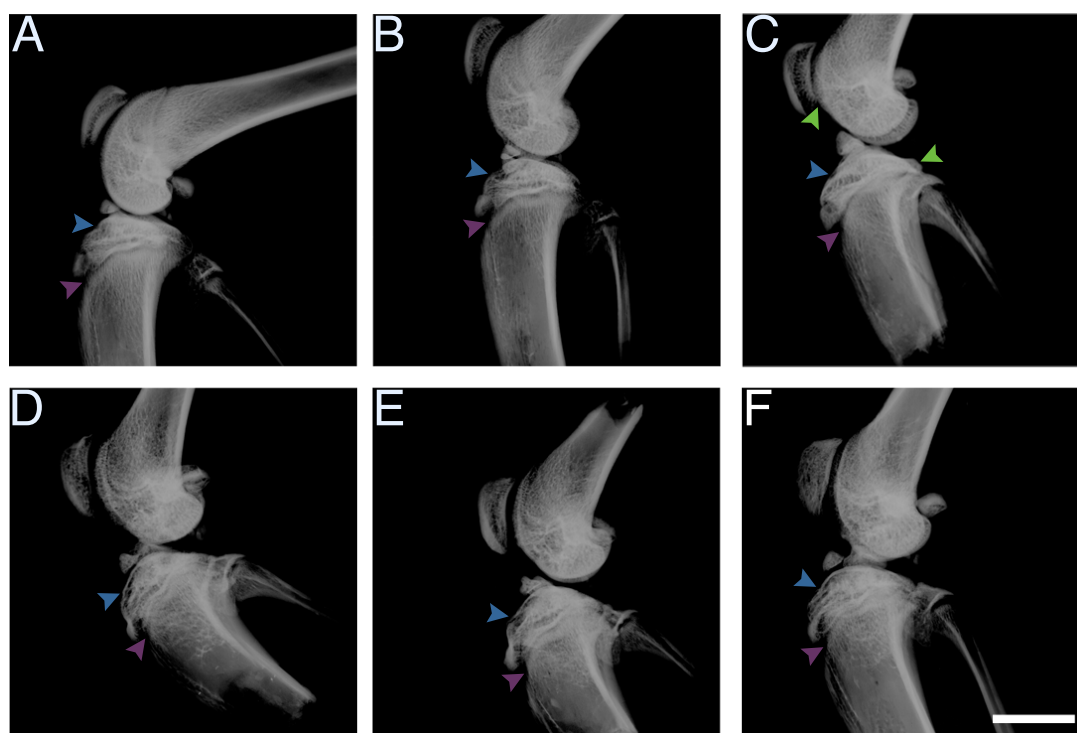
Dual antagonist treatment improves radiological indices of OA: X-ray results. A) no surgery and saline treatment; B) sham surgery and saline treatment; C) ACLT and saline treatment; D) ACLT and BQ-123 treatment; E) ACLT and R-954 treatment; F) ACLT and BQ-123+R-954 dual treatment. Blue arrows indicate tibial plateau, purple arrows indicate subchondral bone, and green arrows indicate osteophytes. Sagittal views. Scale bar, 1 cm.
